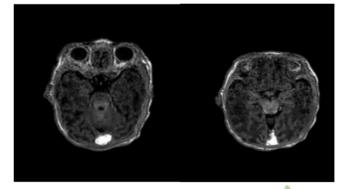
Postnatal MRI: Axial views of the thrombus at Torcular Herophilus
